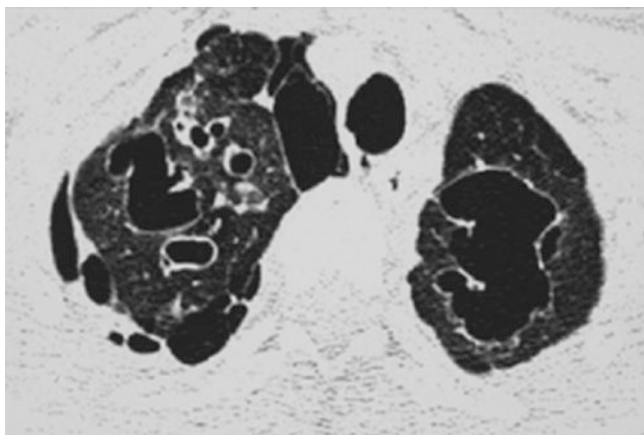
CT post drainage of right apical pneumothorax in patient in Fig. 18.7. There are large bullae in both lung apices
